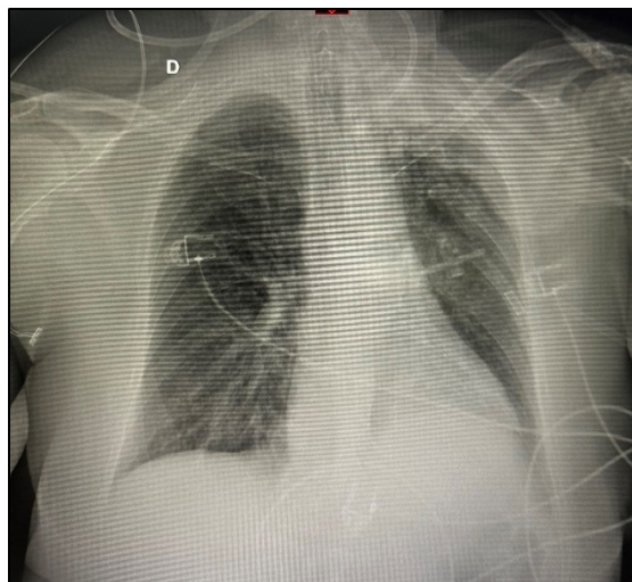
Chest X-ray preoperative.
